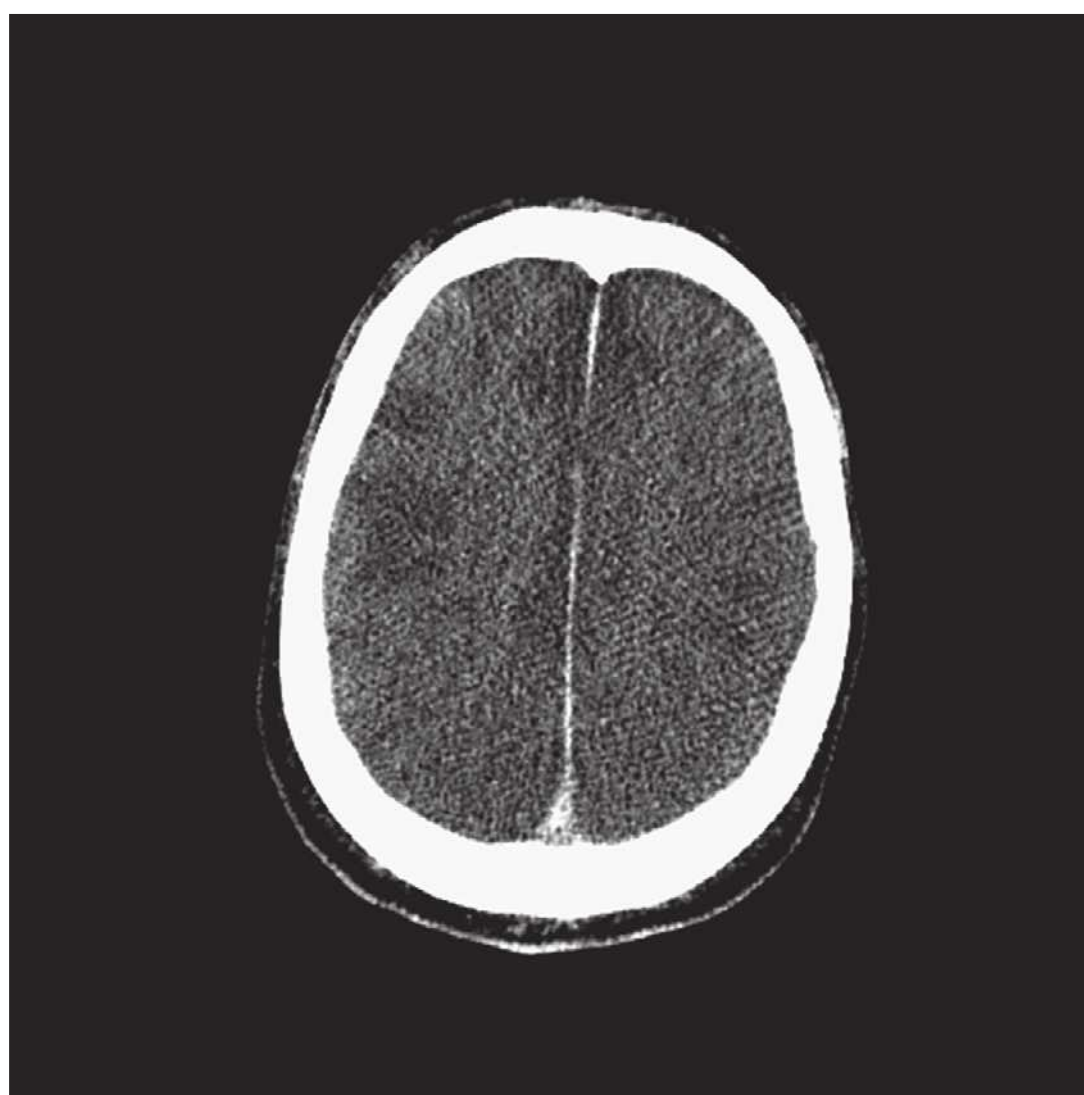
Noncontrast CT scan of patient with anoxic brain injury. Diffuse cerebral edema with loss of grey-white differentiation, obliteration of basal cisterns, multiple areas of hypodensity suggestive of anoxic-ischemic injury, and venous stasis with hyperdensity of the venous sinuses. This patient was brain dead clinically and by apnea testing.
